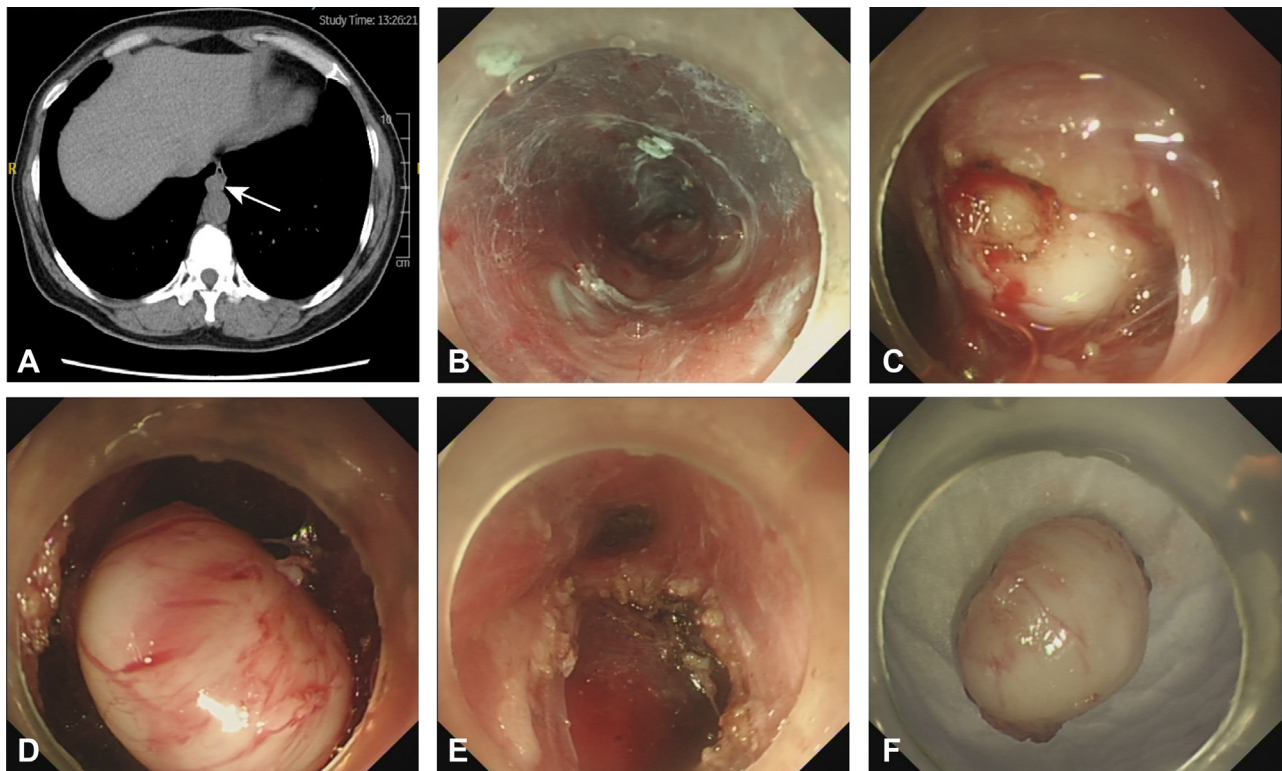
Submucosal tunneling endoscopic resection of an esophageal extraluminal tumor. A, CT showing the location of the extraluminal tumor near the cardia (arrow). B, Established submucosal tunnel 5 cm proximal to the tumor site. C, Exposed tumor after full-thickness myotomy. D, Tumor dissection. E, Endoscopic view in the submucosal tunnel after tumor removal. F, Resected tumor.
